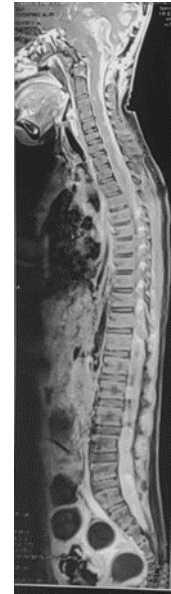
Post-operative MRI spine. The metastatic lesions are causing multifocal cord and thecal sac compression most significant at D2-D3, D11-D12 and L3 to S1 levels. There is evidence of long segmental T2 hyperintensity seen in the cervical cord extending from cervico-medullary junction to C6 vertebral body level.
